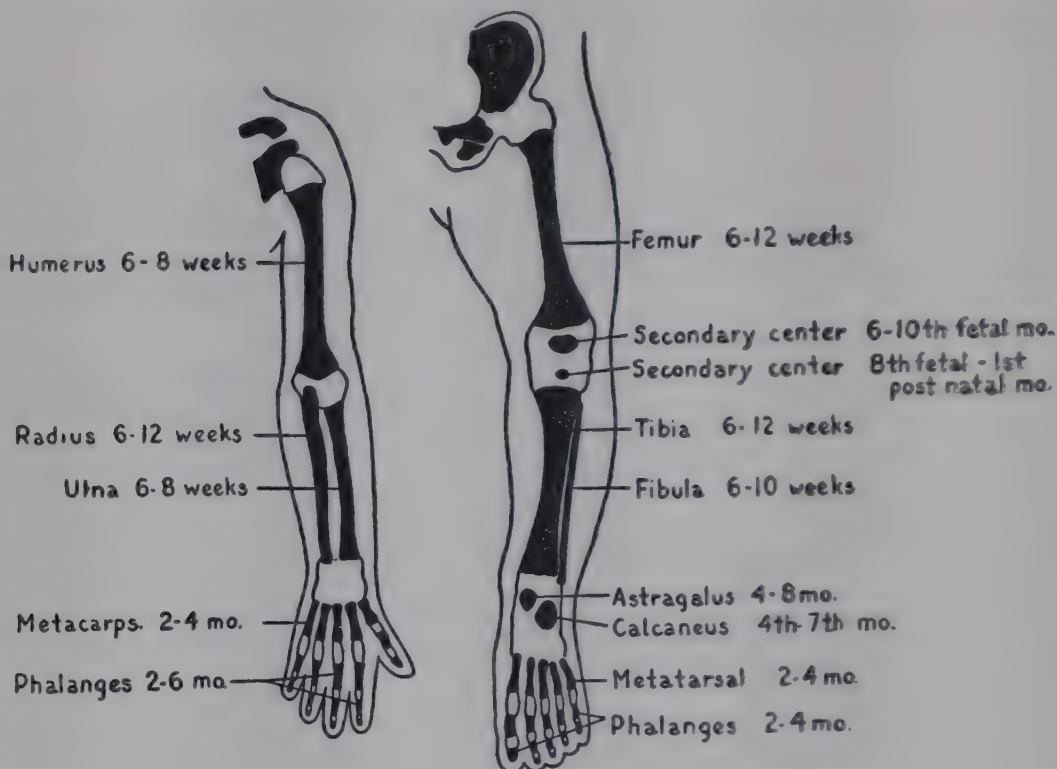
Fetal ossification centers, showing average time of appearance in fetal weeks or months. (From Caffey, J.: *Pediatric X-Ray Diagnosis* [2d ed.; Chicago: Year Book Publishers, Inc., 1950].)
